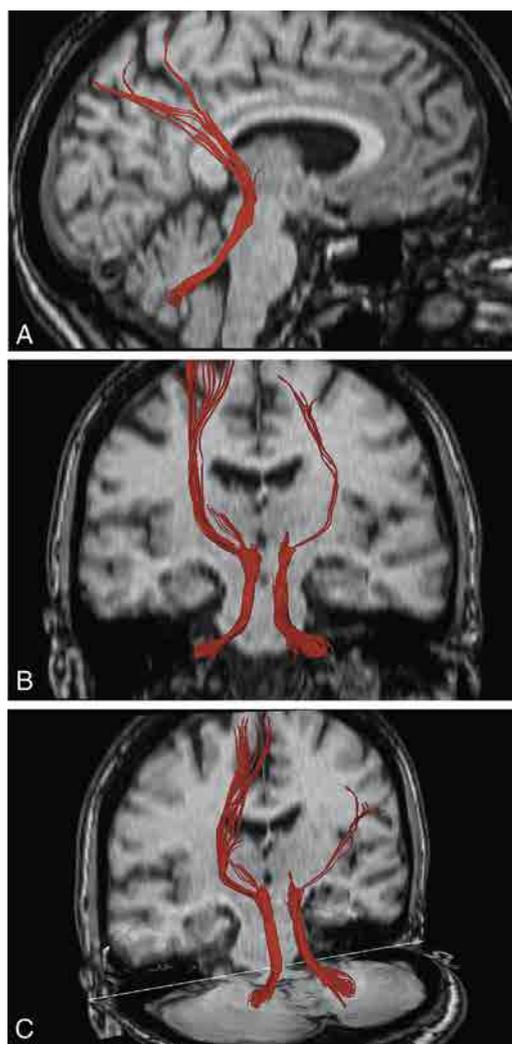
Demonstration of the superior cerebellar peduncles and their thalamocortical projections through DTT images on different brain MRI planes.
